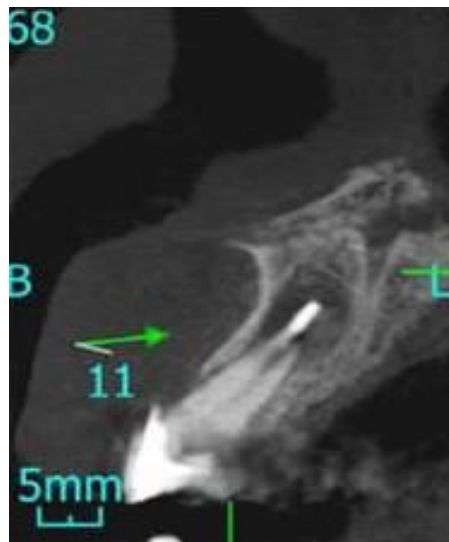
CBCT revealing peri-apical lesion in relation to the endodontically treated tooth in maxillary anterior region.
